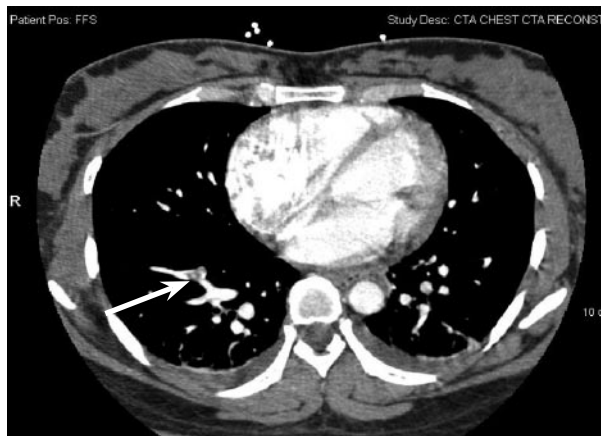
Chest computed tomography scan of patient 2 demonstrating right lower lobe segmental pulmonary embolism (arrow).
